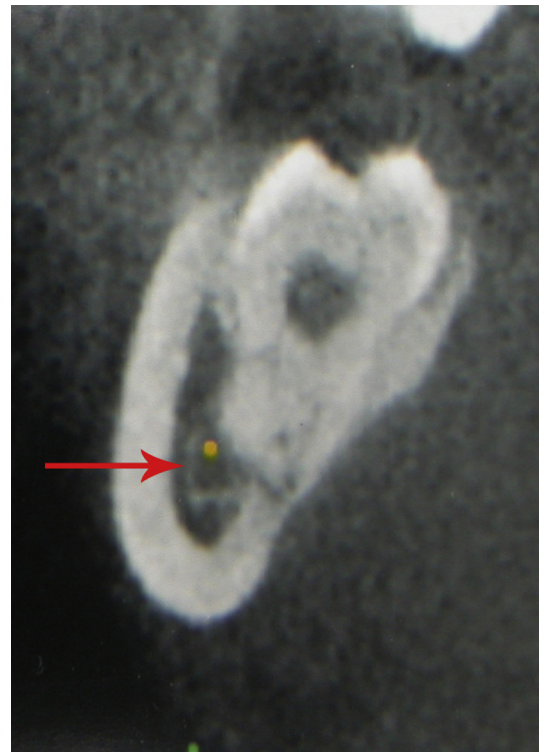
A coronal slice from a cone-beam CT scan showing the inferior alveolar nerve (*arrow*) as separate from the root of the tooth. This represents a low risk of permanent nerve involvement following removal of the tooth.
